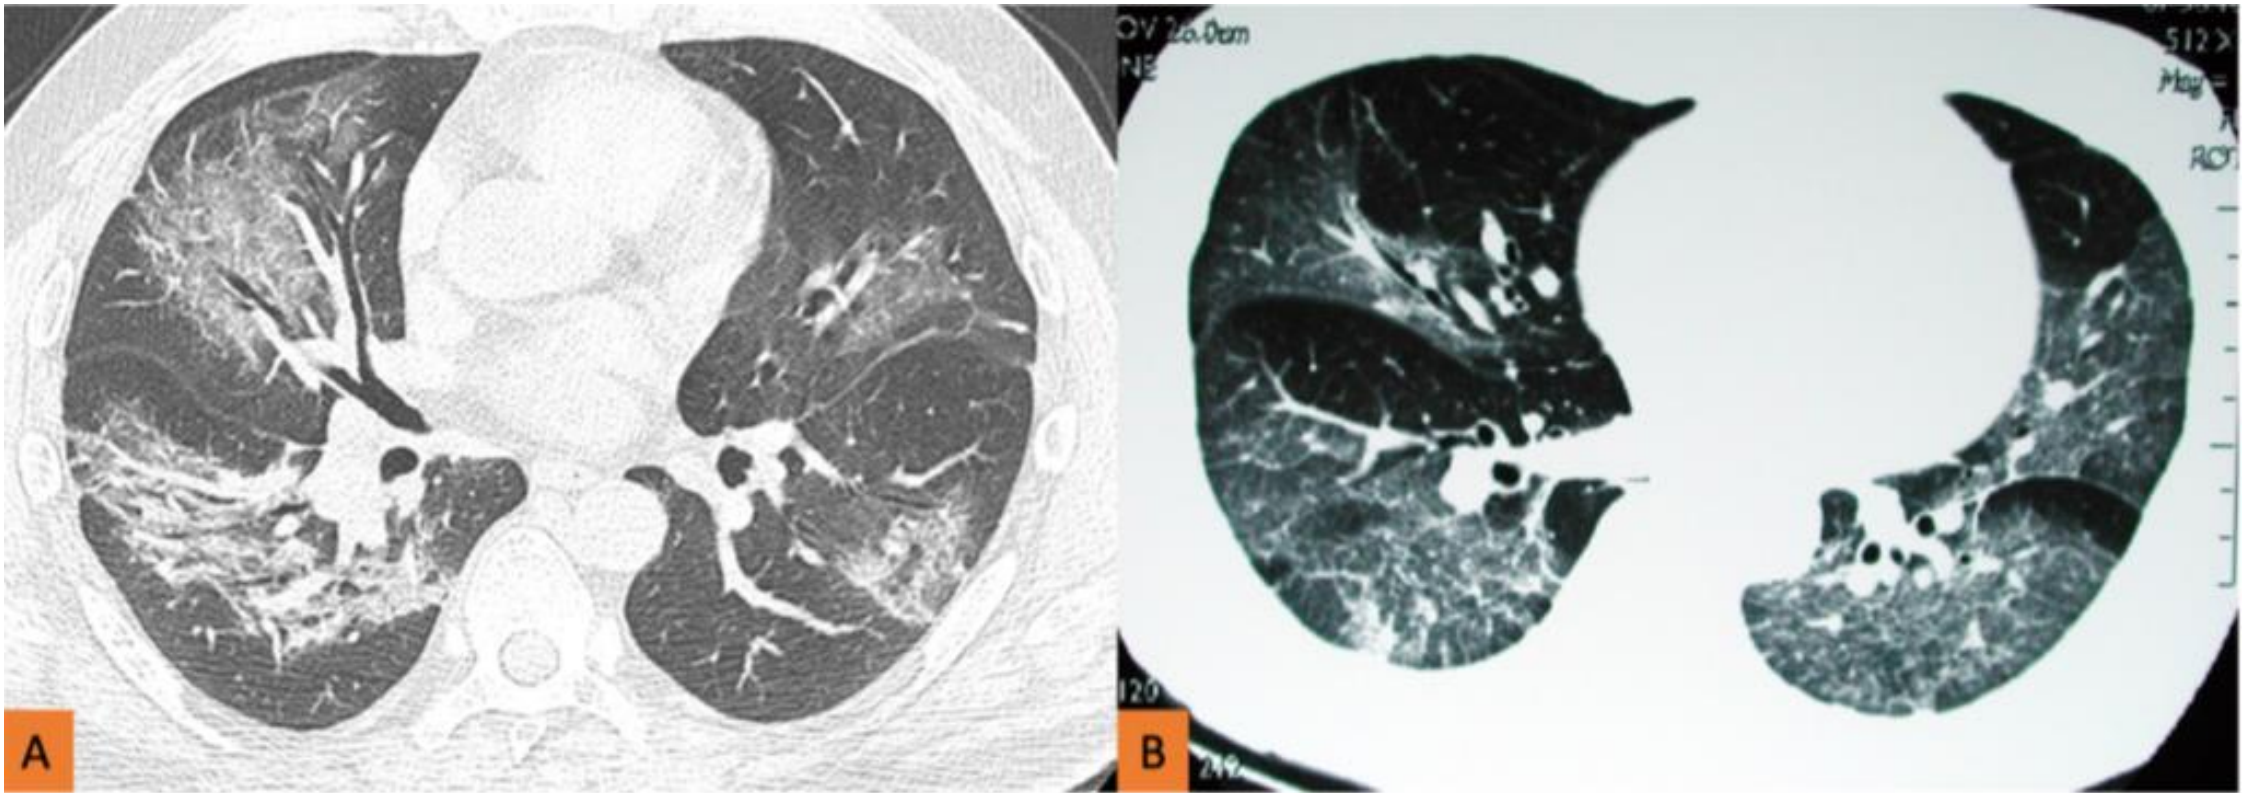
Axial CT images showing a case of COVID-19 (image A) and a case of severe acute respiratory syndrome (SARS) from 2003 (image B). Both cases demonstrate similar predominantly ground-glass opacities affecting both lungs.
